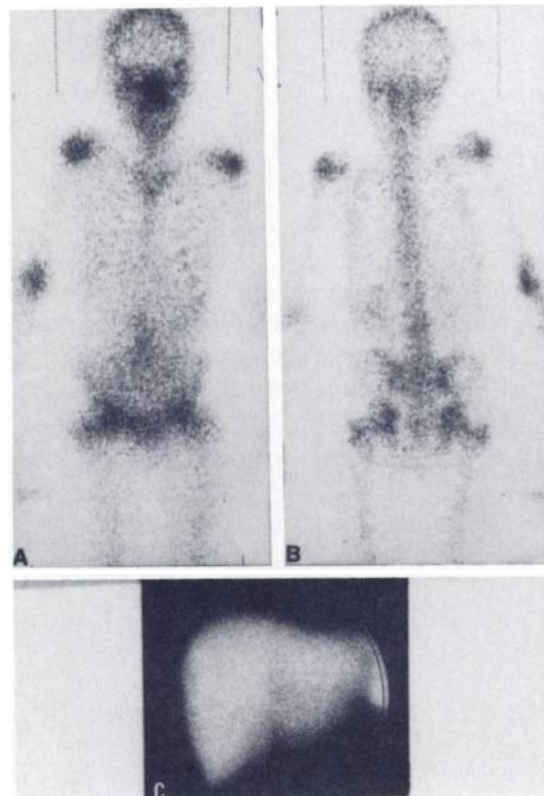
Twelve-year-old boy (Patient 4) with acute lymphoblastic leukemia. Gallium-67 citrate scintigram, (A) anterior and (B) posterior views, show increased uptake by bone and kidneys, diminished uptake by liver, and area of increased activity in right distal humerus. (C) Normal Tc-99m sulfur colloid liver study, anterior view, of same patient.
